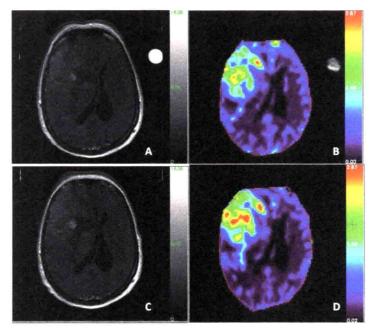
Intraaxial tumor: T1-weighted image (A) with Gd-DTPA showing a brain tumor in the frontal lobe of the right hemisphere; maximum concentration color map for perfusion-weighted image with Gd-DTPA (B). T1-weighted image with gadobutrol (C); maximum concentration color map for perfusion-weighted image with gadobutrol (D).
